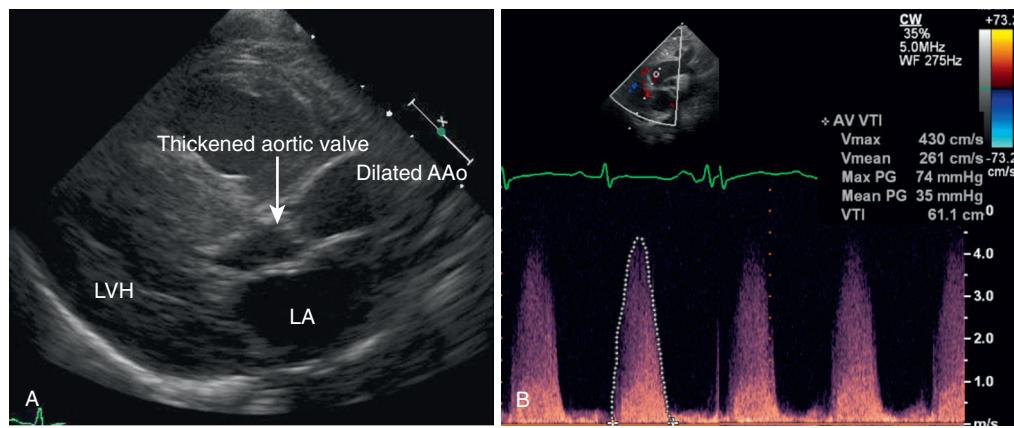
A, Parasternal long-axis view on echocardiogram of an infant with significant valvar aortic stenosis (AS). The valve leaflets are thickened with systolic doming (arrow). There is associated left ventricular hypertrophy (LVH) and ascending aorta (AAo) dilation. LA, Left atrium. B, Continuous-wave spectral Doppler interrogation of the left ventricular outflow tract from the suprasternal notch demonstrating peak velocities up of 4.3 m/sec (74 mm Hg peak gradient, 35 mm Hg mean gradient), consistent with severe AS.
